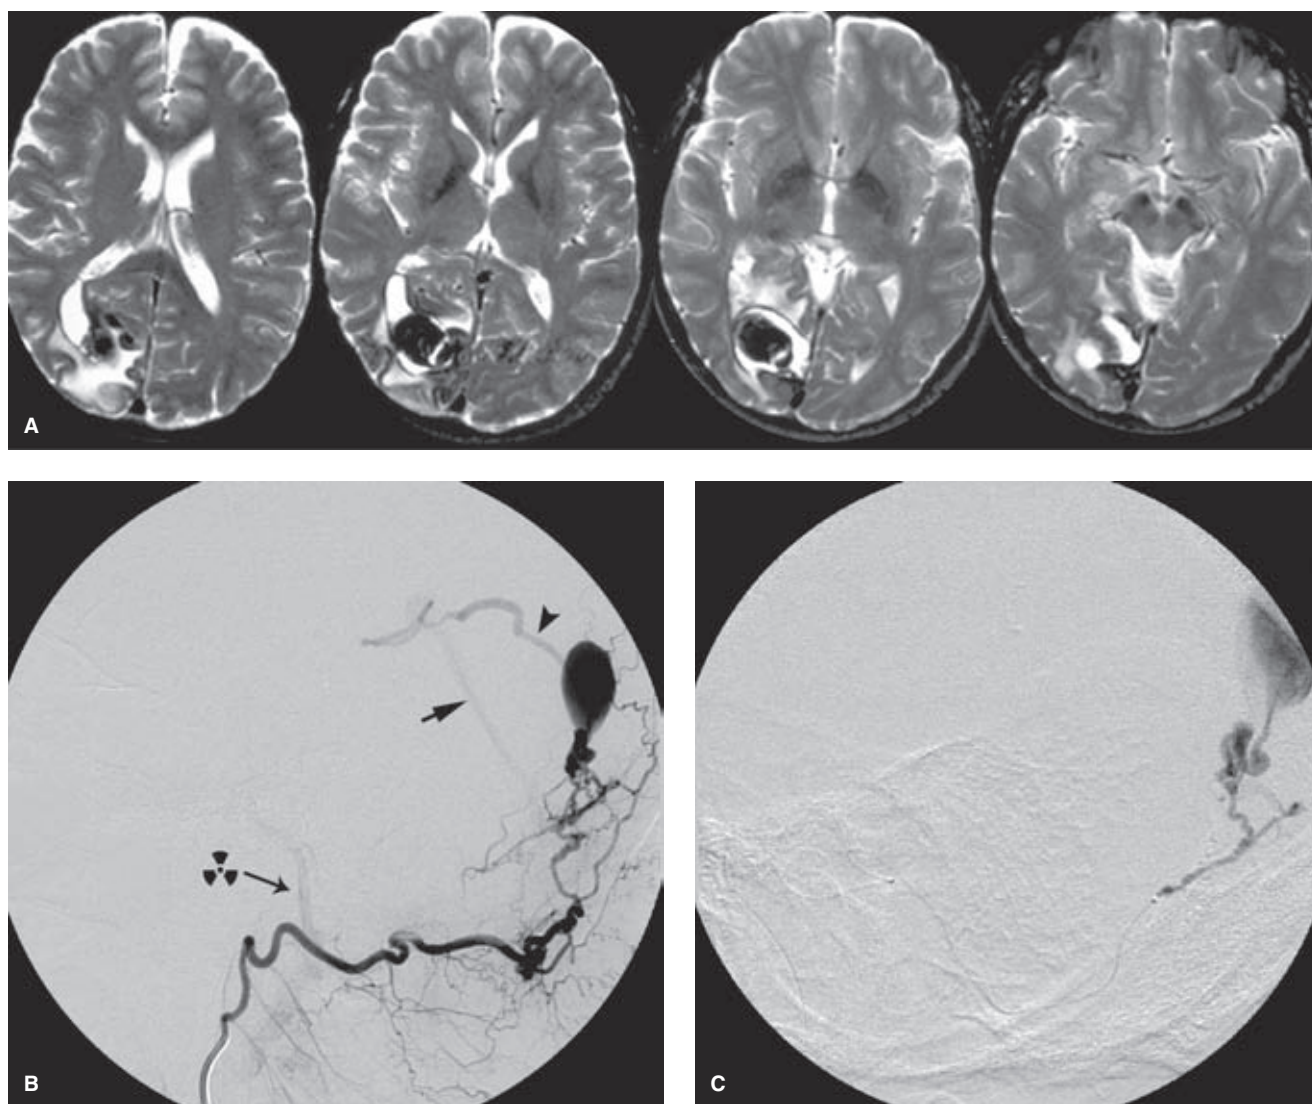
(A–C) Dural AVF mimicking the appearance and clinical presentation of a pial arteriovenous malformation. This middle-aged male patient suffered several hemorrhages of the right occipital lobe over several years before agreeing to endovascular treatment. The T2-weighted MRI (A) shows a profusion of abnormal flow voids, gliosis, and evidence of previous hemorrhage in the right occipital lobe. Note the pulsation artifact in the phase-encoding direction from the dominant intralobar varix. The right occipital artery injection (B) shows the dural AVF to be situated along the posterior tentorium with venous drainage to the right occipital parenchymal veins, including the dominant varix seen on the MRI. A single draining vein (arrowhead) connects the abnormal venous field with the straight sinus (arrow). Notice the transient opacification of the basilar artery (nuclear danger sign) from the occipital artery, a reminder of importance of potential dangerous anastomoses during embolizations. An NBCA embolization from the occipital artery was only partially successful, but the lesion was finished off with a distal NBCA embolization from a dural branch of the right anterior inferior cerebellar artery (C, microcatheter injection showing persistent AVF opacification prior to final embolization with 17% NBCA via a Spinnaker Elite microcatheter).
